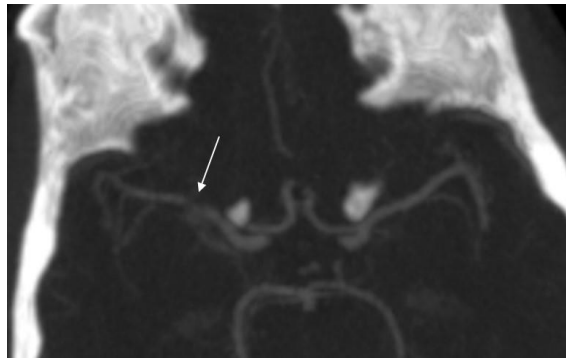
CTA showing the presence of right MCA narrowing (arrow) suggestive of intracranial stenosis or marginized thrombus.
